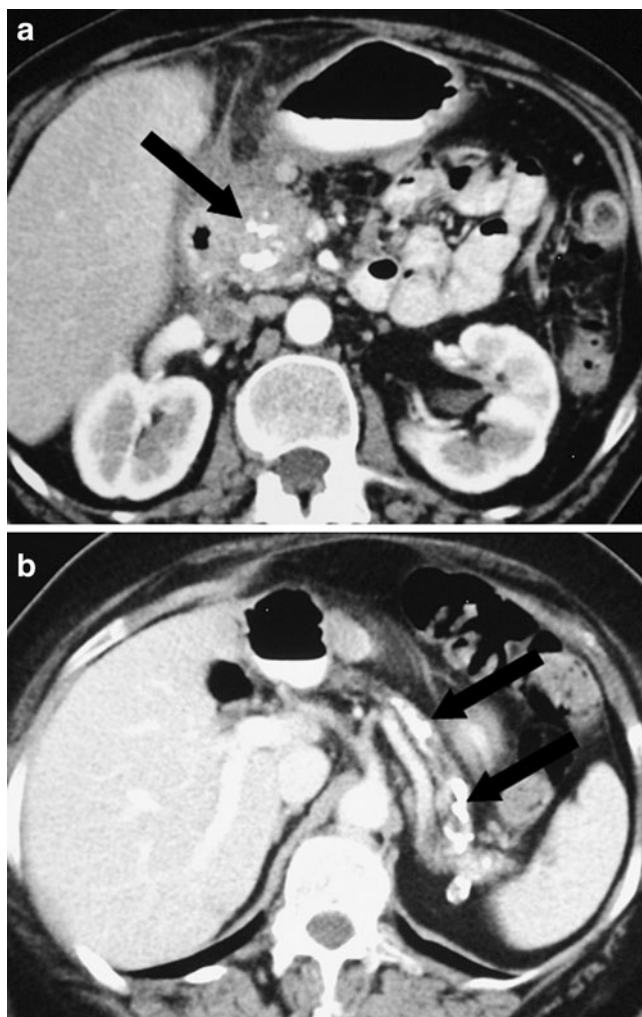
Preoperative CT scans show indications for redo procedure. a 30 months after distal pancreatectomy, this patient underwent Whipple operation due to pancreatitis in the remnant pancreas with calcification of the head of pancreas (arrow). b 33 months after Whipple operation, this patient underwent redo-Whipple operation due to calcification and atrophy of the remnant pancreas with concretions in the pancreatic duct (arrow)
